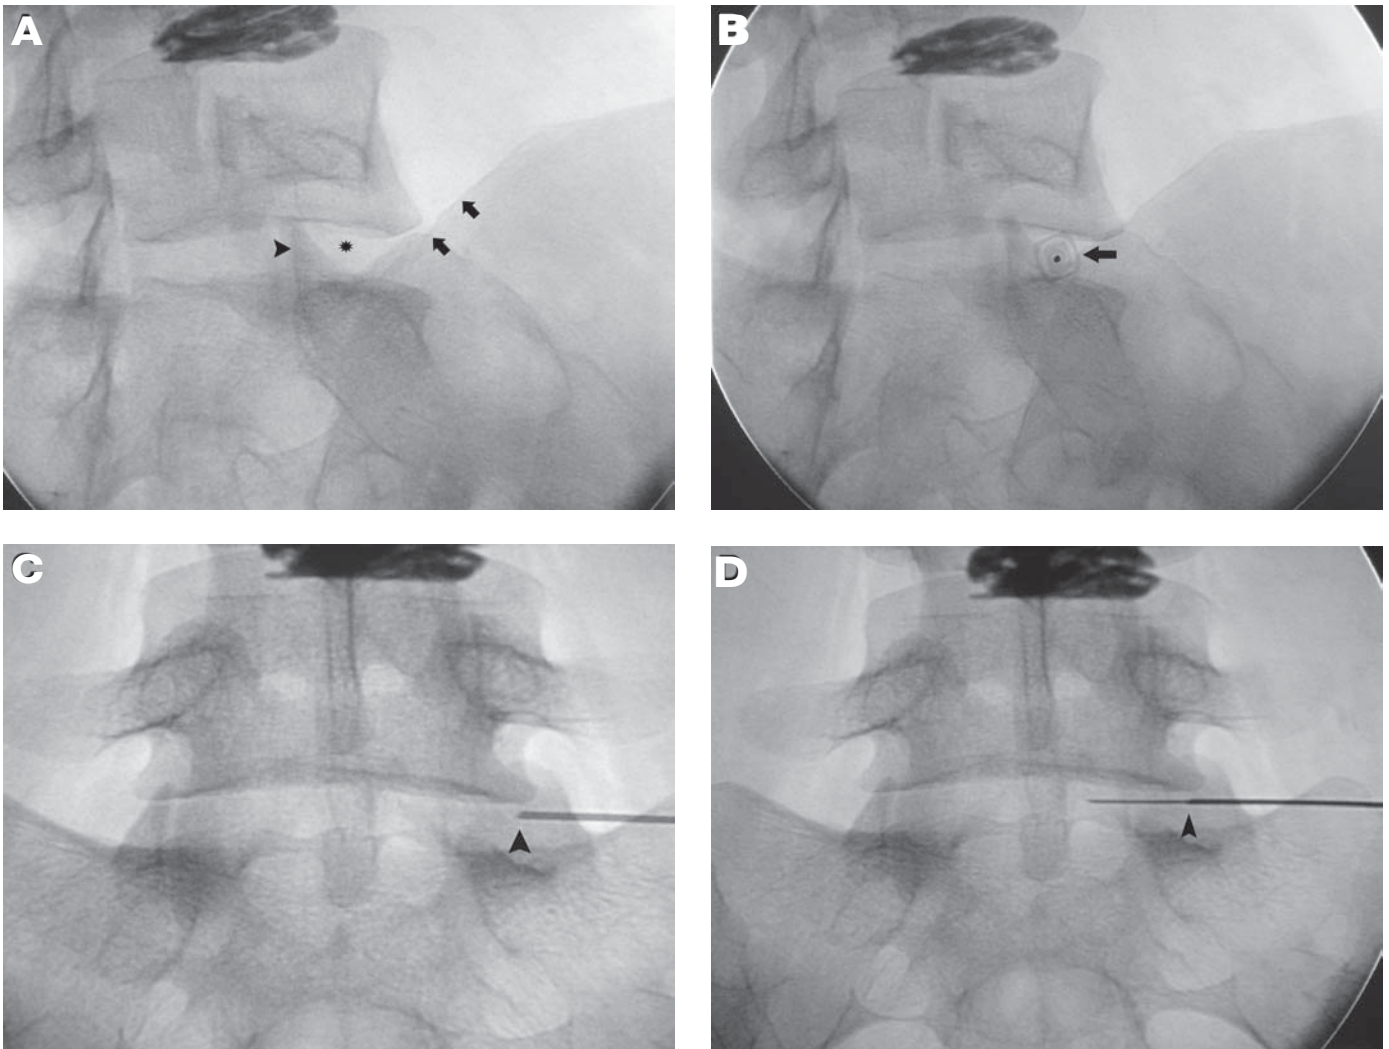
Lumbosacral junction approach. (A) The fluoroscopic beam is oriented with caudal angulation and is rotated slightly to open a small triangle of access over the iliac crest (*arrows*). The target zone (*asterisk*) is the disc just anterior to the superior articular process (*arrowhead*) of the overlying facet joint. (B) The outer needle (*arrow*) is advanced down the X-ray beam until it comes in contact with the outer annulus. (C) The image intensifier is then rotated into the frontal projection. The outer needle is located at the outer annulus (*arrowhead*). The inner needle is now inserted into the nucleus (D) Occasionally, a curve will be needed with the inner needle to facilitate needle entry into the nucleus.
